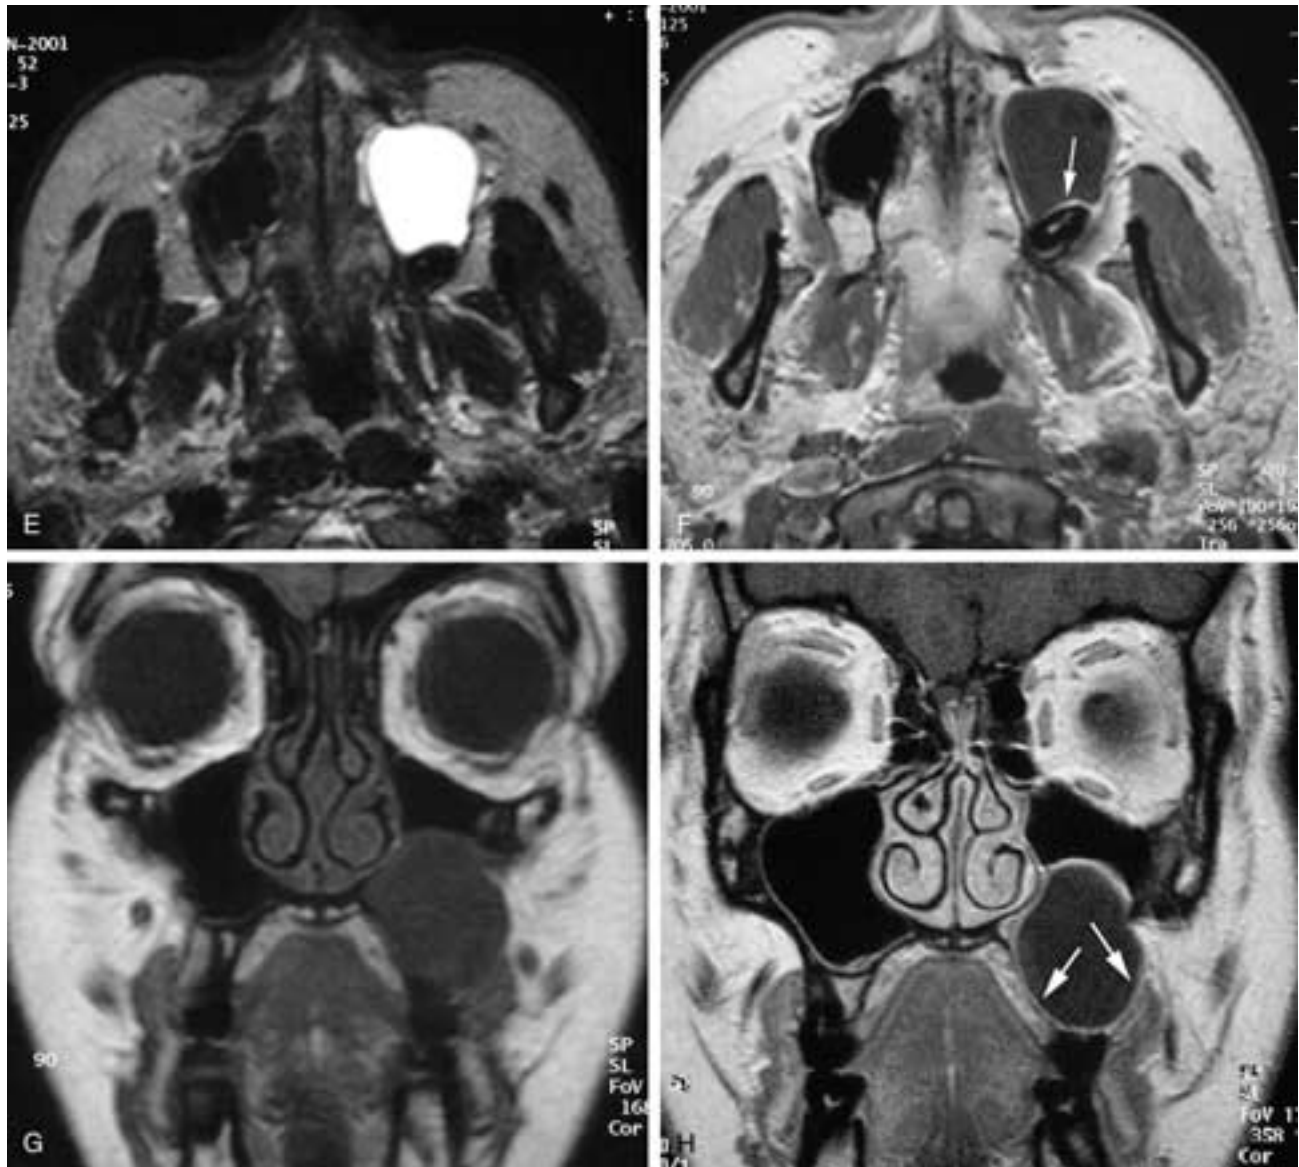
Continued.* E, The lesion is homogeneously bright on this T2-weighted image. OKC can also be heterogeneous. F, Axial T1 postgadolinium image shows a thin, regular enhancing margin (*arrow*) borders and “covers” the tooth. G, Coronal T1-weighted image. H, Coronal T1-weighted image after gadolinium enhancement shows the thin, regular enhancing wall (*arrows*) of the keratocyst.
